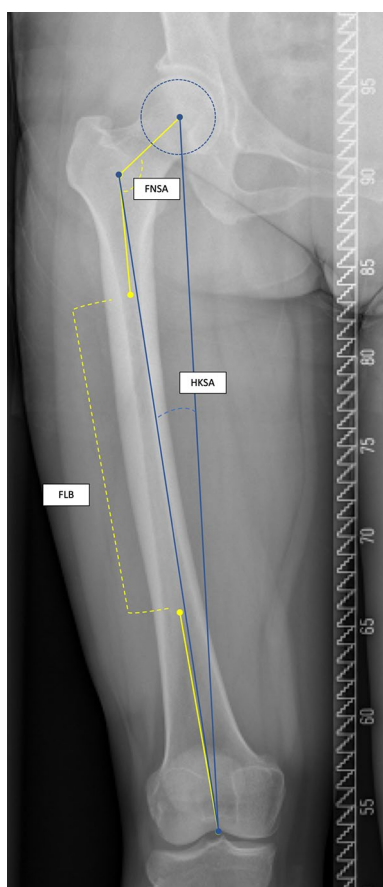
Femur geometrical parameters on X-ray. Femoral lateral bowing: angle between axes of 20% proximal and distal sections of femur diaphysis; Femoral neck shaft angle: angle between the femoral neck axis and mechanical axis of the femur. Hip-knee-shaft angle: angle between mechanical and anatomical femoral axes
